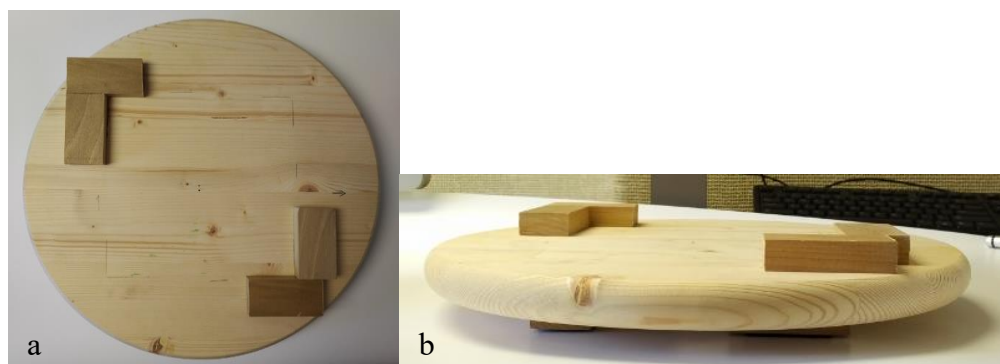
(a) Top-down view of the wooden mount used for positioning the apparatus in the MRI, (b) Side view of the wooden mount used for positioning the apparatus in the MRI.
